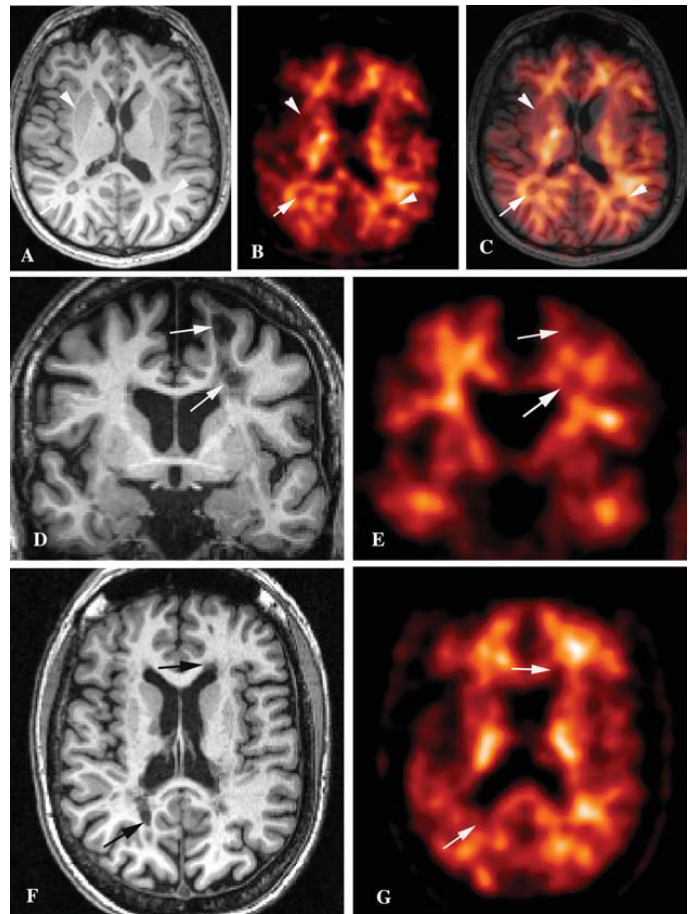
MP-RAGE 3T MRI and C11-PiB PET images for MS patient 1 (A-C) and MS patient 2 (D-G); reprinted from Stankoff et al. (2011).
